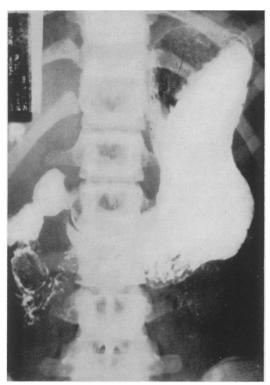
Radiograph demonstrating filling defect in the second portion of the duodenum.
